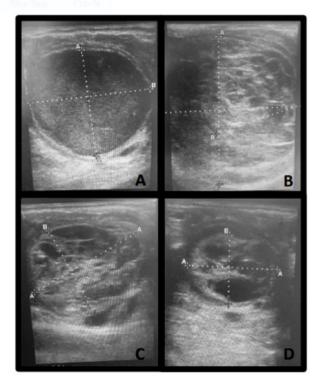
Ultrasonographic progression of the HAF.* Various stages of development of the HAF are depicted. (A) One day prior to ovulation and formation of the HAF, the preovulatory follicle (49.5x44.5-mm) presented with an echogenic pattern within the follicular fluid. (B) Day 0 of the cycle of interest was characterized by a prominent fibrin network and the largest diameter of the HAF (68.6x61.3-mm). (C) Various patterns of the fibrin network were visible with the persistence of the HAF (47.7x39.4-mm). (D) The decrease in size of the HAF was accompanied with growth and dominance of another follicle on the contralateral ovary (36.2x27.1-mm).
